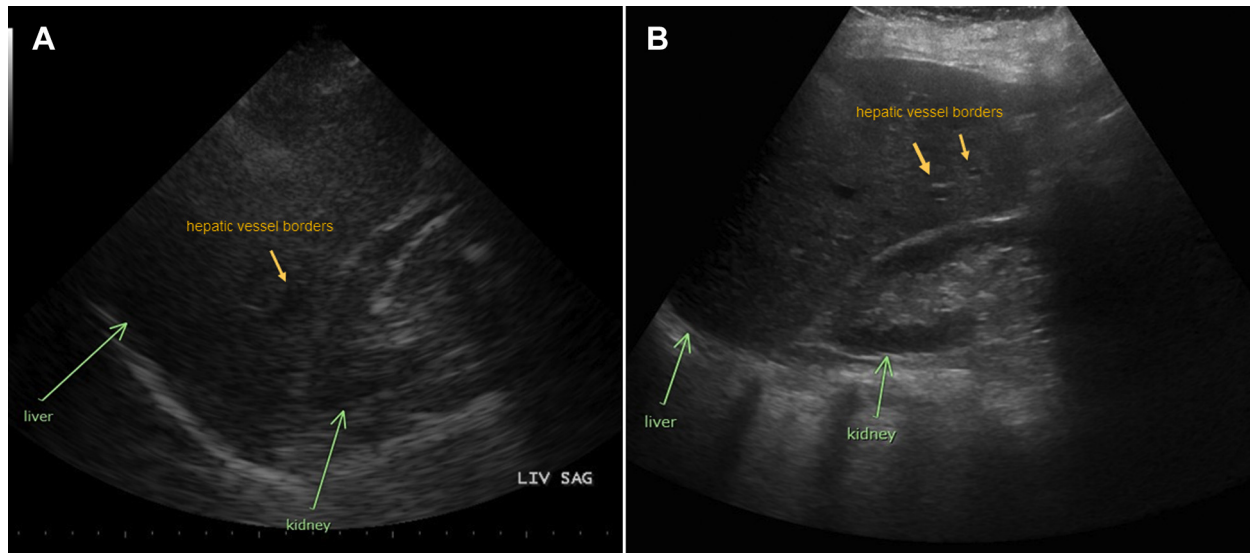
Findings of abdominal ultrasound imaging of liver steatosis before (A) and after mifepristone treatment (B). Green arrows indicate the liver and kidney. Yellow arrows point to the hepatic vessel borders. Reduced echogenicity of the liver parenchyma with periportal enhancement is observed after mifepristone treatment.
